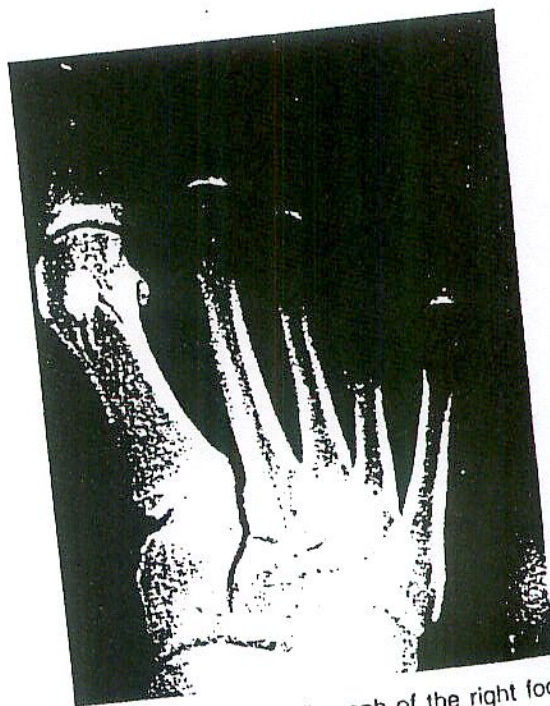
Anteroposterior radiograph of the right foot, demonstrating shortened fourth metatarsal.
